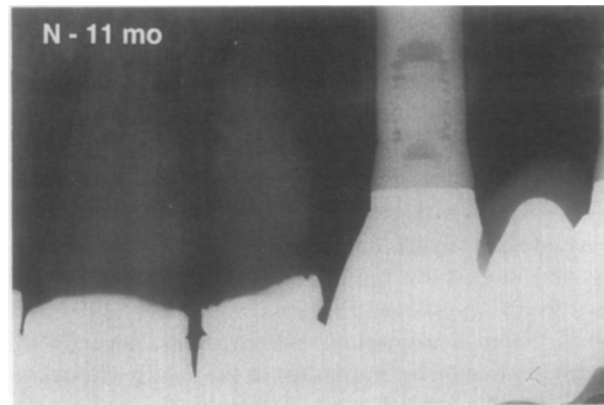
Radiograph at 1 month indicates diminution of space between lateral incisor coping and superstructure (N - 11 months).
